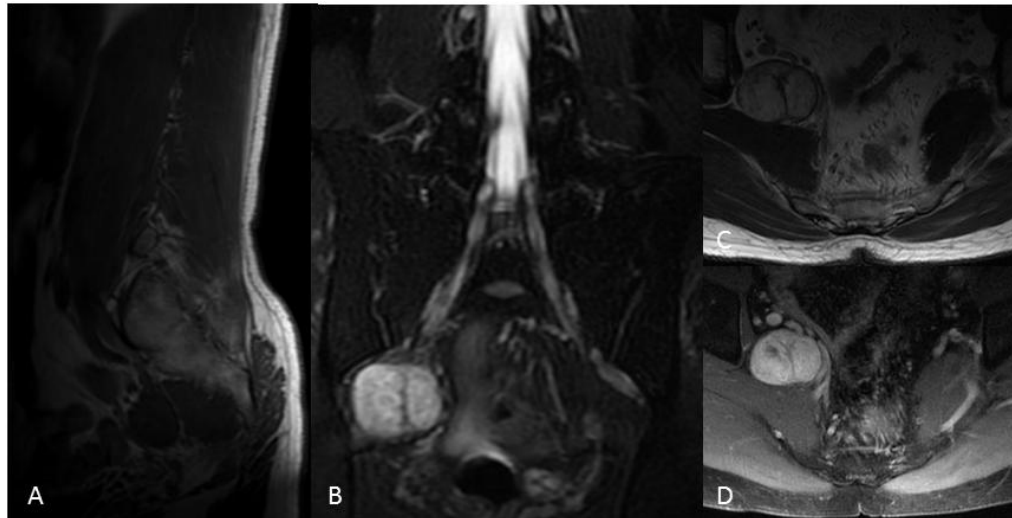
Preoperative magnetic resonance imaging of the lumbar spine showing a 30 × 38 × 32 mm-sized intraextrapelvic mass under the right piriformis muscle (A-D). (A) Sagittal T1-weighted imaging; (B) Coronal T2-weighted imaging; (C) Axial T2-weighted imaging; (D) Axial T1-weighted and contrast-enhanced fat-saturation imaging.
